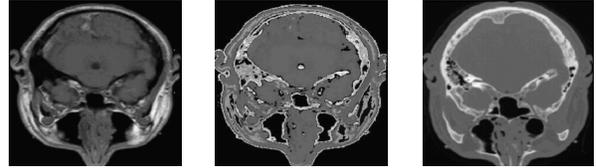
(a) Original MRI image. (b) Transformed MRI image. (c) Original CT image. The transformed MRI (center) matches the geometry of the original MRI (left) and the intensity profile of the CT scan (right).
